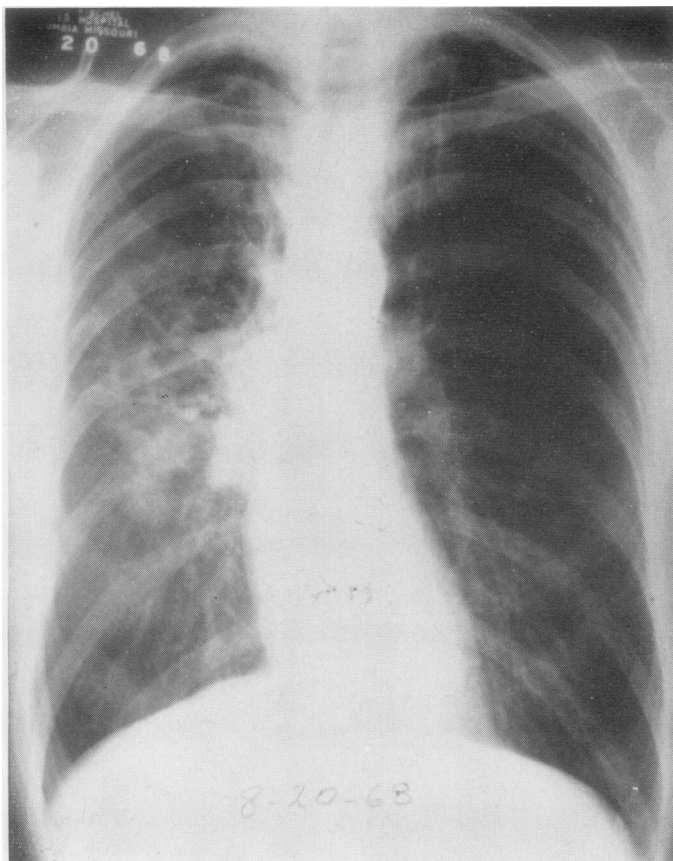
Chest radiograph (20/8/68) shows pulmonary infiltration in the right lung.
